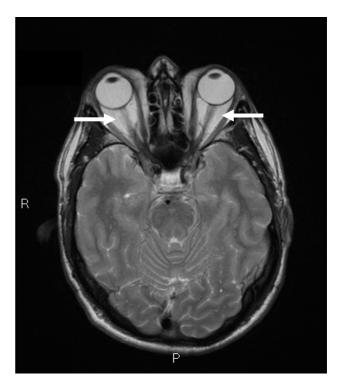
Figure I Magnetic Resonance Imaging of the orbits, showing congestion of the retro-orbital space and enlargement of the extraocular muscles (arrows), consistent with the diagnosis of Graves' Ophthalmopathy.
